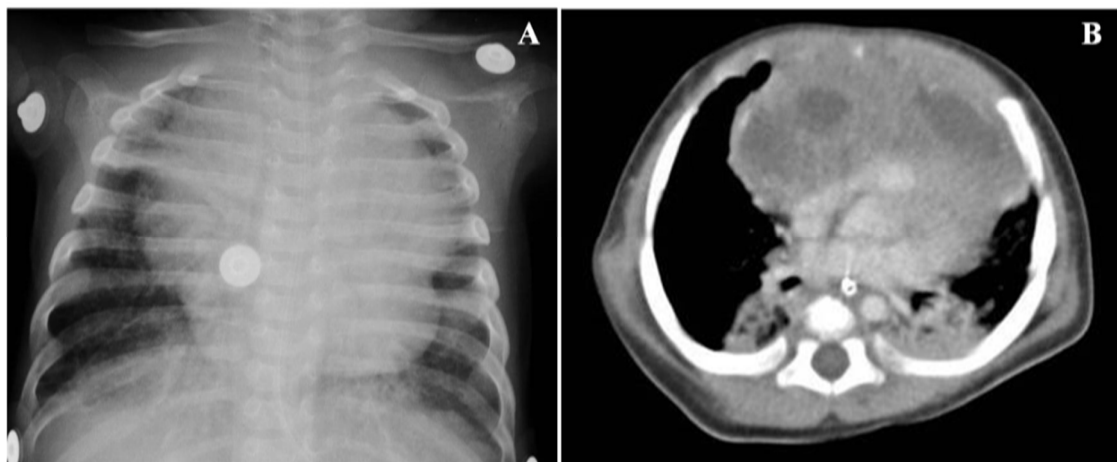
Mediastinal mass on Chest Radiograph (A).
